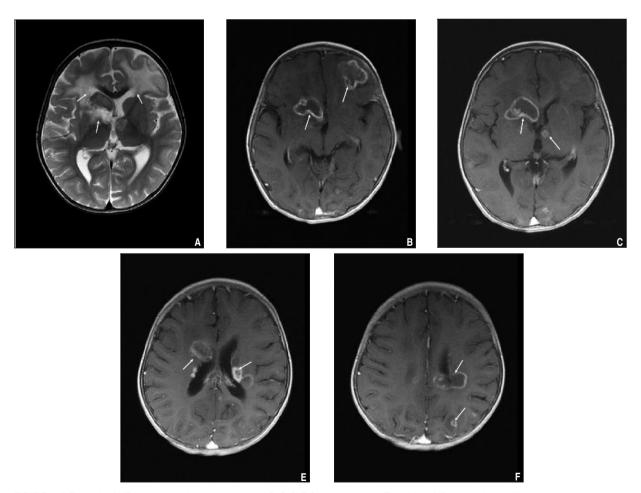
A. T2 weighted MR image shows hyperintense lesions. B, C, D, E Contrast enhanced T1 weighted MR images show multiple enhancing mass lesions.
